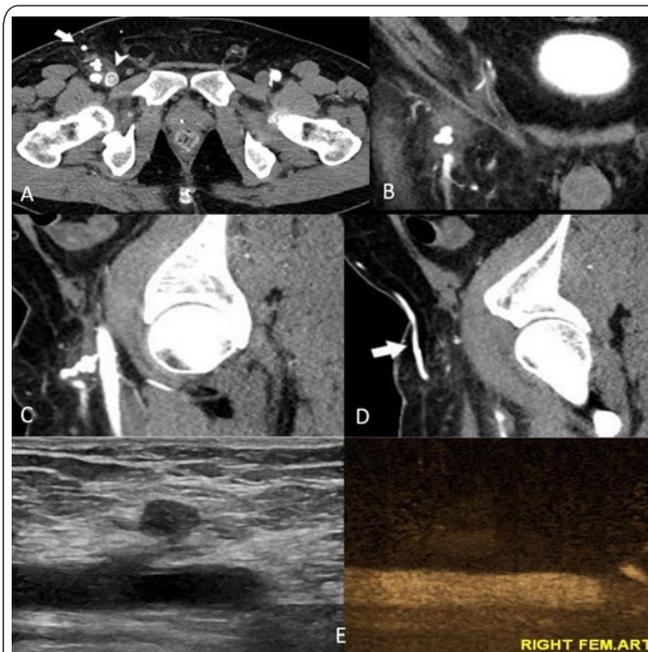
A CT angiogram of the abdomen demonstrates a pseudoaneurysm which measures 13 x 10 x 13 mm with a narrow and long neck, approximately 7 mm in length, arising from the right CFA [Images A (axial), B (coronal), C (sagittal)]. The pseudoaneurysm communicates with a cluster of blood-filled sacs and was complicated by fistulisation to the right inferior epigastric vein (Images A and D – arrow). Contrast drainage is also identified in the right common femoral vein (Images A – arrow head). Manual compression of the pseudoaneurysm was performed and the follow-up ultrasound the following-day demonstrates complete thrombosis of the pseudoaneurysm (Image E).
